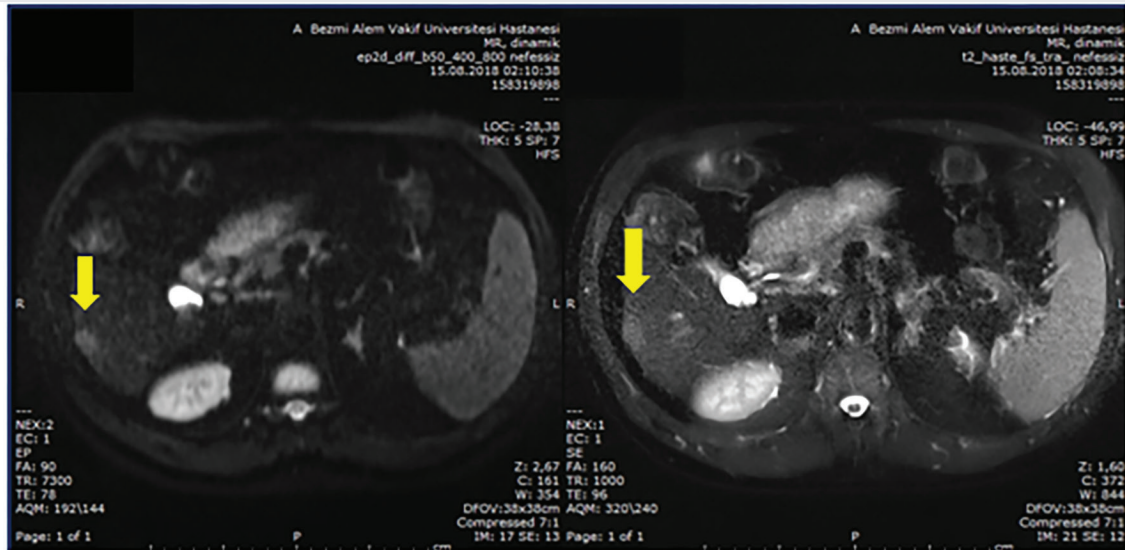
Axial magnetic resonance imaging demonstrating a 27×22 mm lesion located peripherally in segment VI of the right hepatic lobe, consistent with the post-ablation zone following radiofrequency ablation
